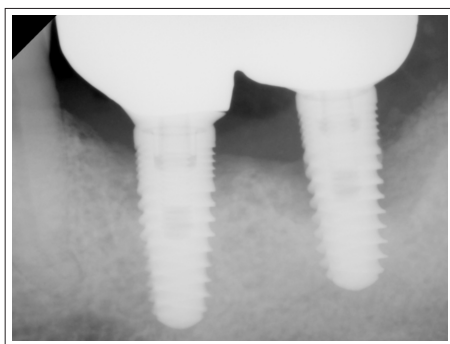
Initial presentation x-rays
